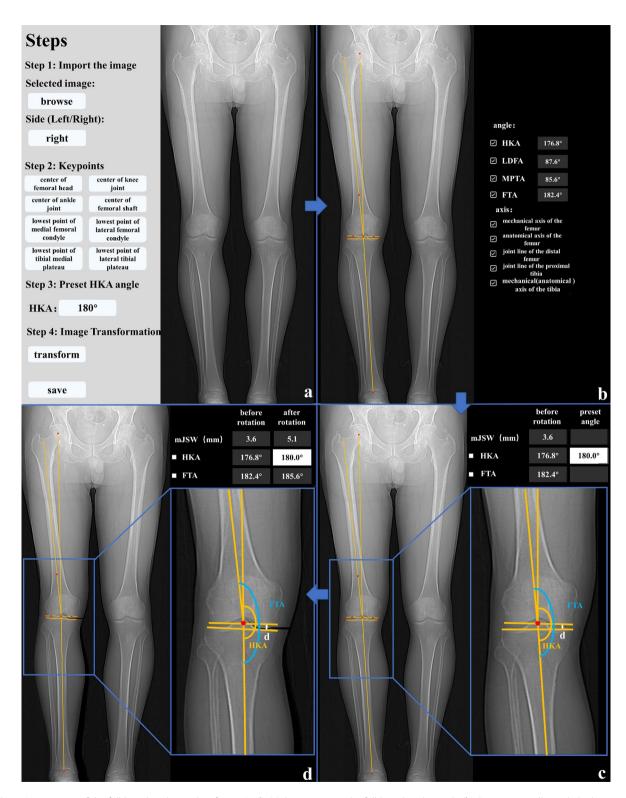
Usage steps of the full-length radiograph software (a-d). (a) Step 1, import the full-length radiograph; (b) Step 2, manually mark the key points, automatically connect the axes and calculate the angles; (c) Step 3, manually preset the angle of hip–knee–ankle angle (HKA), and automatically the original HKA, femoral tibial angle (FTA) and medial joint space width (mJSW); (d) Step 4, recognize and segment the tibia and fibula, automatically rotate the tibia and fibula to the preset HKA, and display HKA, FTA, and mJSW after rotation
